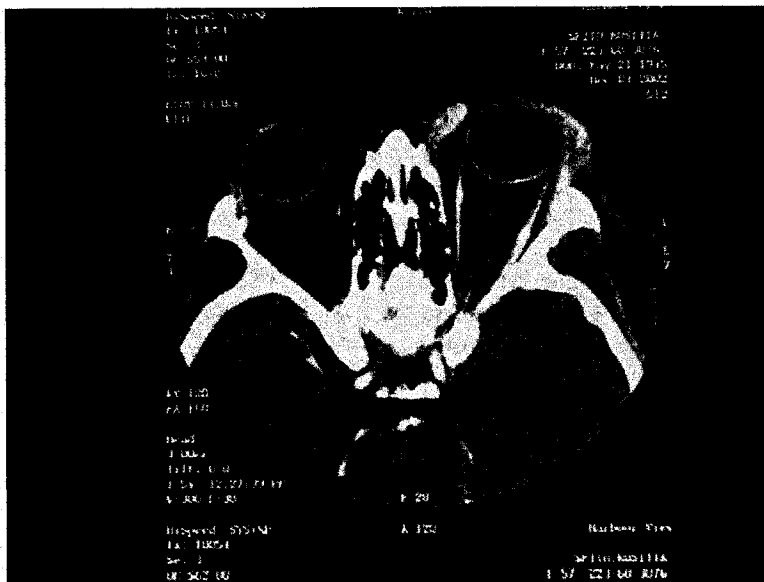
CT scan showing periorbital swelling on left.
